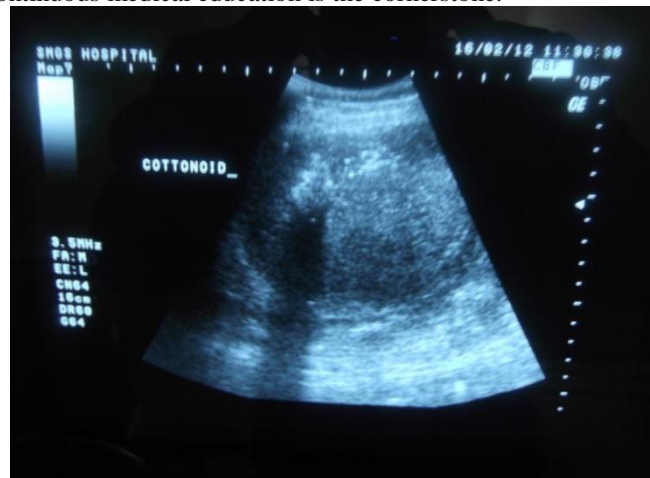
Ultrasonography of abdomen showing well defined rounded heterogeneous mass lesion with internal hyperechoic foci representing air bubbles and distal acoustic shadowing.
